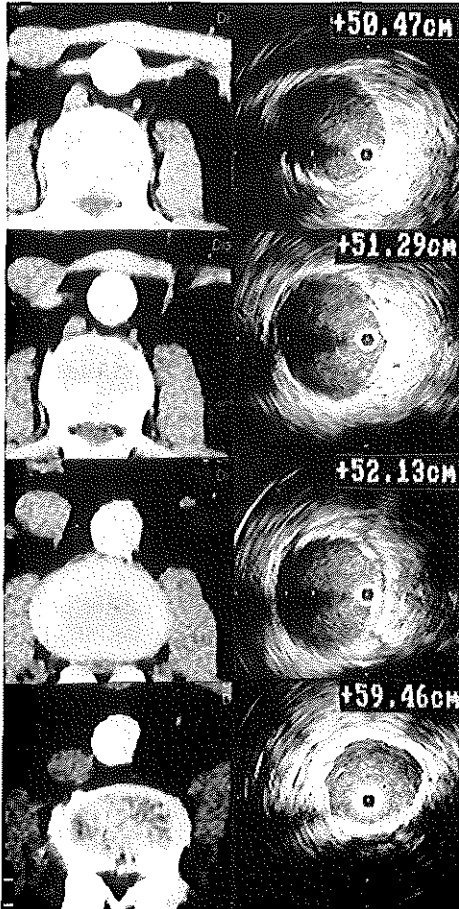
Intravascular ultrasound cross-sections and computed tomographic angiography counterparts of the proximal and distal neck of an abdominal aortic aneurysm. *Upper panel* shows the cross-section 0.2 cm below the most distal renal artery. The *second panel* shows a cross-section halfway in the proximal neck. The *third panel* shows a cross-section 0.2 cm proximal to the aneurysm. The *lower panel* shows a cross-section 1 cm distal to the aneurysm. *Inserts* show the reading from the displacement sensing device. Calibration on CTA: 10 mm. Calibration on IVUS: 5 mm.
